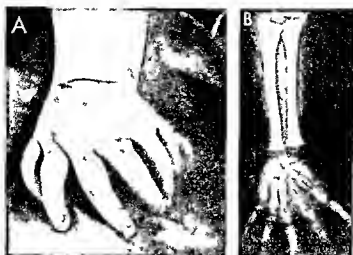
285 — Infantile ulnar dimelia. In A, photograph of the hand at 3 weeks of age, there are seven fingers. In B, radiograph of the hand and forearm at 4 years of age, the ulnas are paired.
